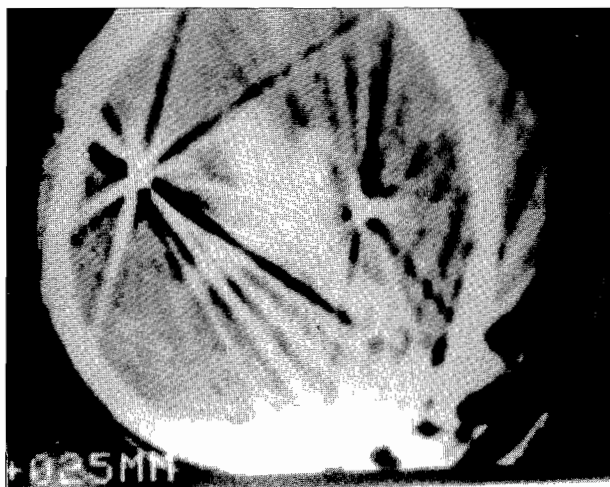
Non contrast enhanced axial Brain CT showing soft tissue swelling on the left multiple metallic shrapnels (bullets) are present within the brain parenchyma. They are seen casting streaky artefacts over the brain thereby degrading the quality of the image and making detailed intracranial evaluation difficult. Associated intraventricular haemorrhage is demonstrated centrally in the background.
